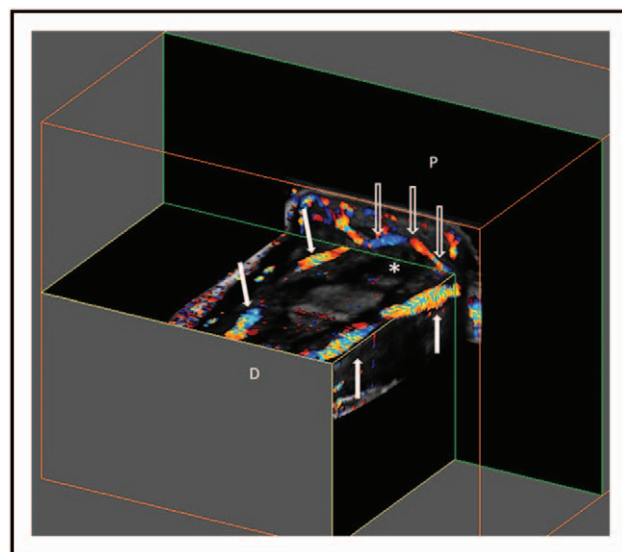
Three-dimensional musculoskeletal ultrasonography (3D MSUS). 3D MSUS examination of the palmar interphalangeal part of the right hand's second finger, which demonstrates two digital arteries (white arrows) and a transverse feeding vessel (open arrows). *Flexor tendon and sheath. Distal (D), proximal (P).
